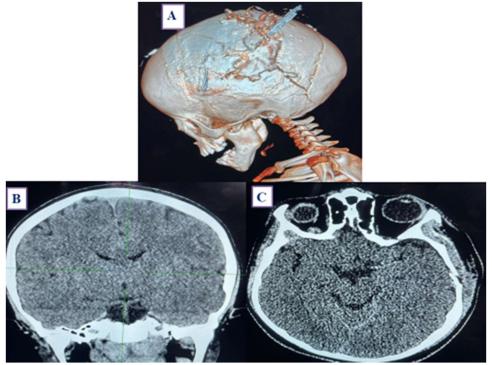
Normal CT of different patients came to ER Trauma, fall, assault, then scan and imaging finding was A) Normal axial brain CT scan. B) Normal axial Brain CT Scan. Nasal septum deviation as incidental findings. C) Normal axial Brain CT Scan of patient fall down. No skull vault fracture
